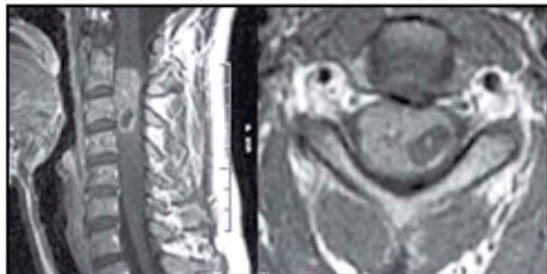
MRI scan of the cervical spine revealed a large, partially cystic, enhancing intramedullary tumor at C2-C3.
